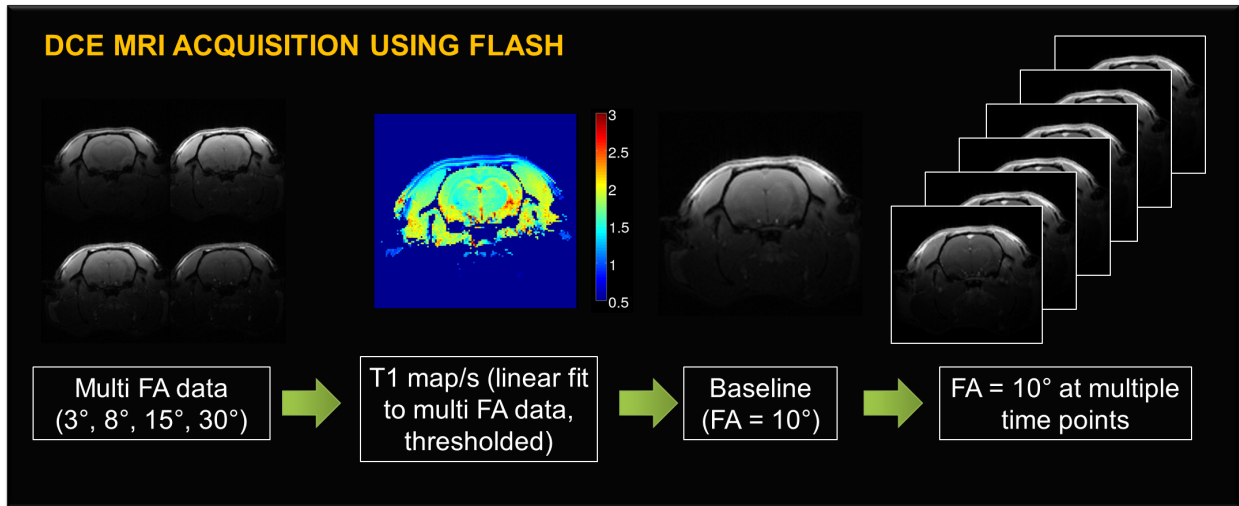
Stages of DCE MRI acquisition, beginning with VFA FLASH and using this to form a baseline T1 map. The FLASH signal baseline is then taken and the signal ratio between the baseline and scans taken after contrast agent has been administered is used to calculate the apparent T1 due to the presence of contrast agent during the dynamic scan.
